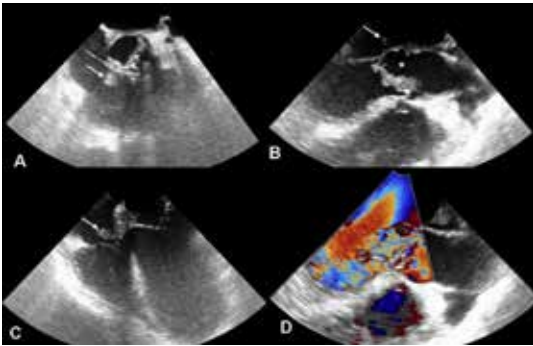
Transesophageal echocardiography short axis, three chamber long axis and four chamber long axis view revealed aortic non-coronary cusps destruction (asterisk, 1B), severe aortic regurgitation (1D) and vegetations (arrows, 1A, B, C).
